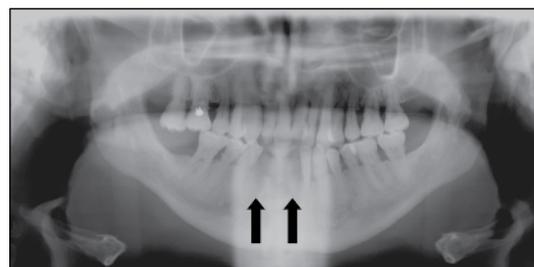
Dental radiograph showing nonhealing of extraction sites (arrows) in the anterior mandible—findings consistent with jaw osteonecrosis in this patient, who was treated with monthly intravenous bisphosphonate therapy.
